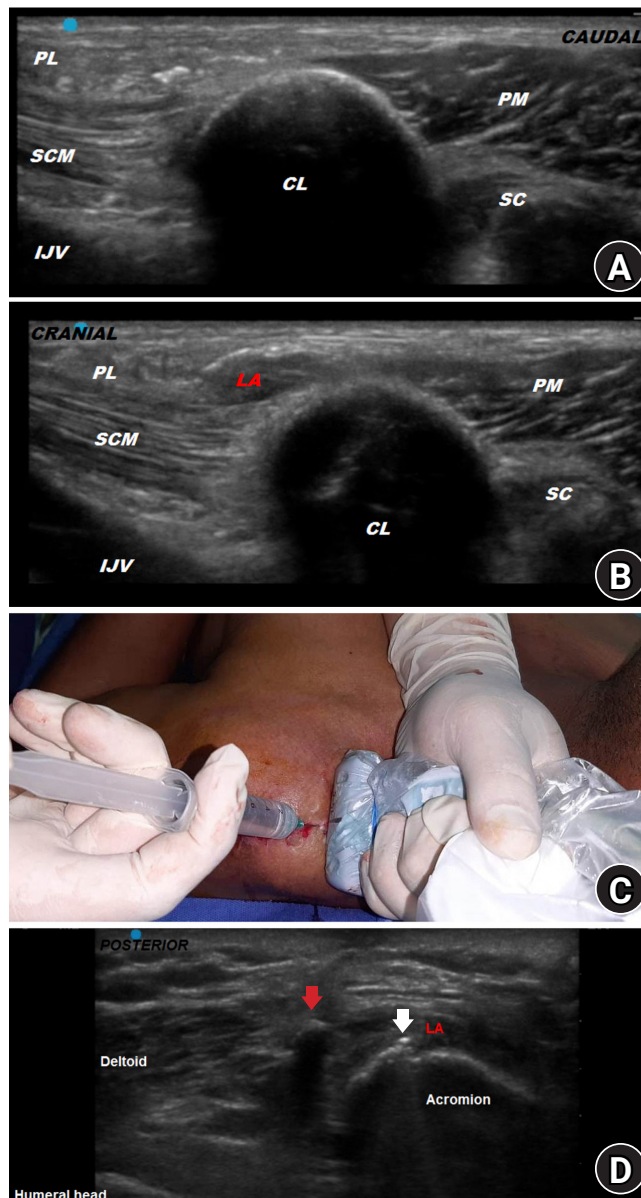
Ultrasound-guided WALANT. A needle was inserted to contact the clavicle. After confirming proper position of the needle, local anesthetic was injected under real-time ultrasound guidance. (A) Sagittal cross section sonogram of the clavicle and (B) the modifications after subperiosteal injection showing a thickened and less echogenic cortical line with fuzzy edges. (C) Patient position and needle insertion for the out-of-plane technique performed at the lateral portion of the clavicle. All needle redirections are performed through the same insertion site. (D) Image showing the Kirschner-wire at its entry point as a hyperechoic structure with a comet-tail artifact (white arrow) and the hyperechoic tension band wire with an acoustic shadowing behind (red arrow). Note the typical thickening and echotexture change of the acromial cortical line after subperiosteal injection. CL: clavicle, IJV: internal jugular vein, LA: local anesthetic, PL: platysma muscle, PM: pectoralis major muscle, SCM: sternocleidomastoid muscle, SC: subclavius muscle.
